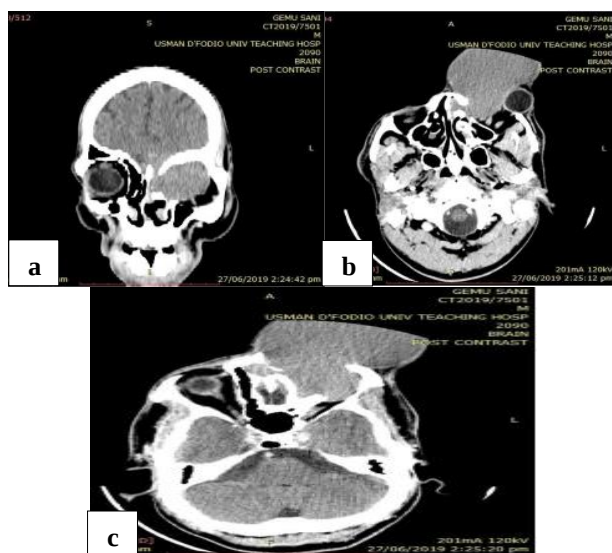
CT scan of the paranasal sinus and brain (a) coronal view of isodense lesion in orbit, frontal sinus and intracranial extension, (b) axial view with isodense lesion displacing the globe, and (c) isodense lesion involving the left ethmoid and globe on axial view.
